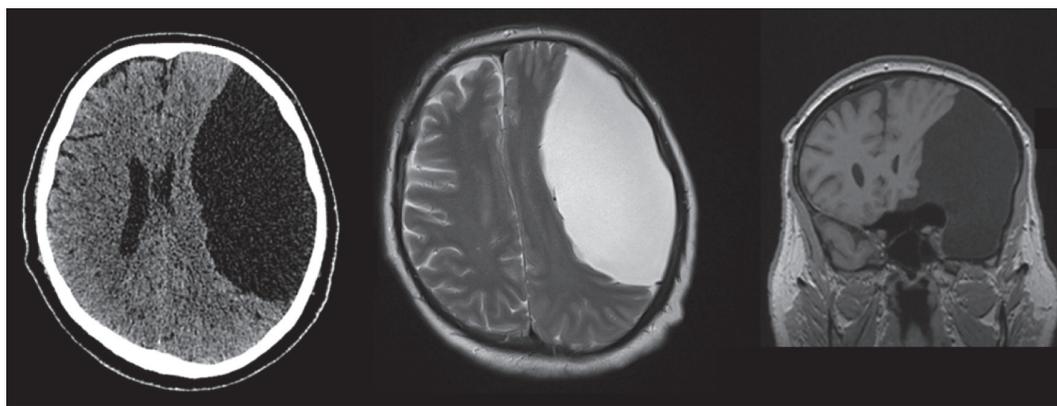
Computed tomography (CT) scan and magnetic resonance (MR) imaging before the first surgery showing a large fronto-temporo-parietal arachnoid cyst, although differential diagnosis includes tumor and hygroma
